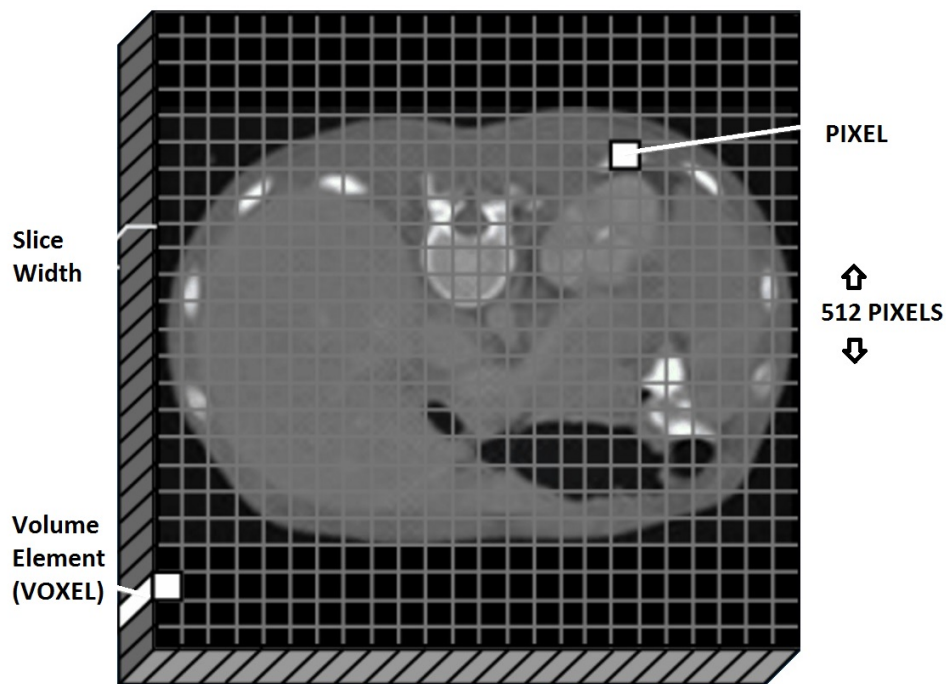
CT Slice consisting of pixels (*Physics Central* 2016).
